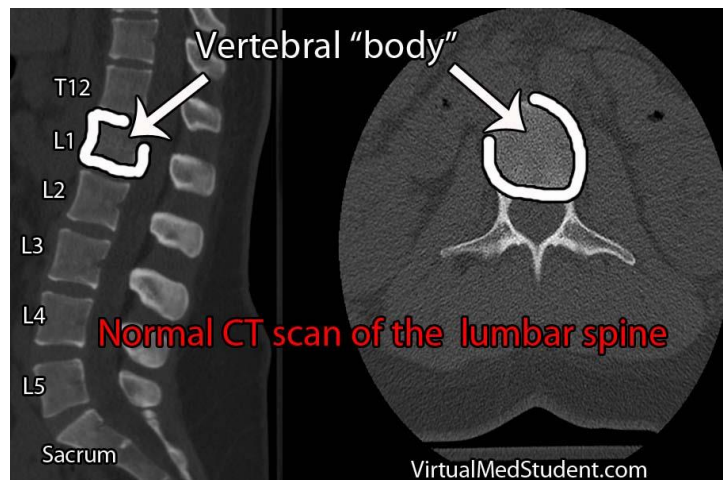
Normal CT of Lumbar spine (Pansky B , et al 1996)
